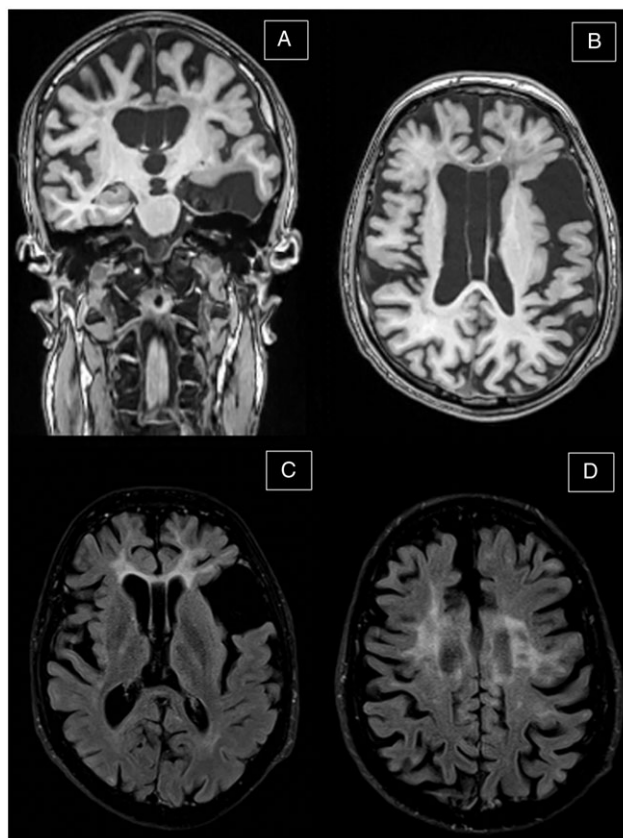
Index case MRI. On top, coronal (A) and axial (B) T1-weighted MRI showing frontoparietal atrophy, cavum vergae, and right temporopolar arachnoid cyst. On bottom, two different axial (C, D) T2-weighted fluid attenuated inversion recovery (FLAIR) MRI showing symmetrical mainly periventricular prominent frontal leukoencephalopathy.
